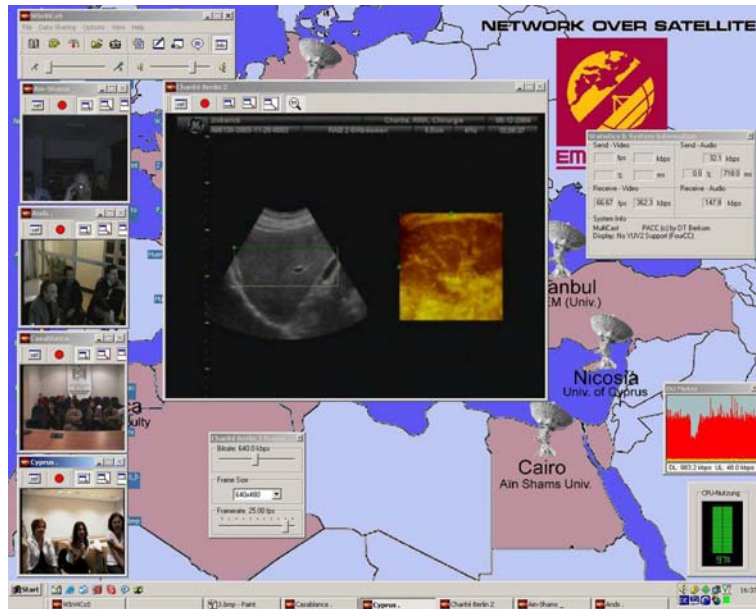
e-Learning session with transmission of live ultrasound video streams from Charité (Berlin) to Ain Shams University (Cairo), Agence Nationale de Documentation de la Sante (Algiers), Faculte de Medecine et de Pharmacie (Casablanca) and University of Cyprus (Nicosia)
